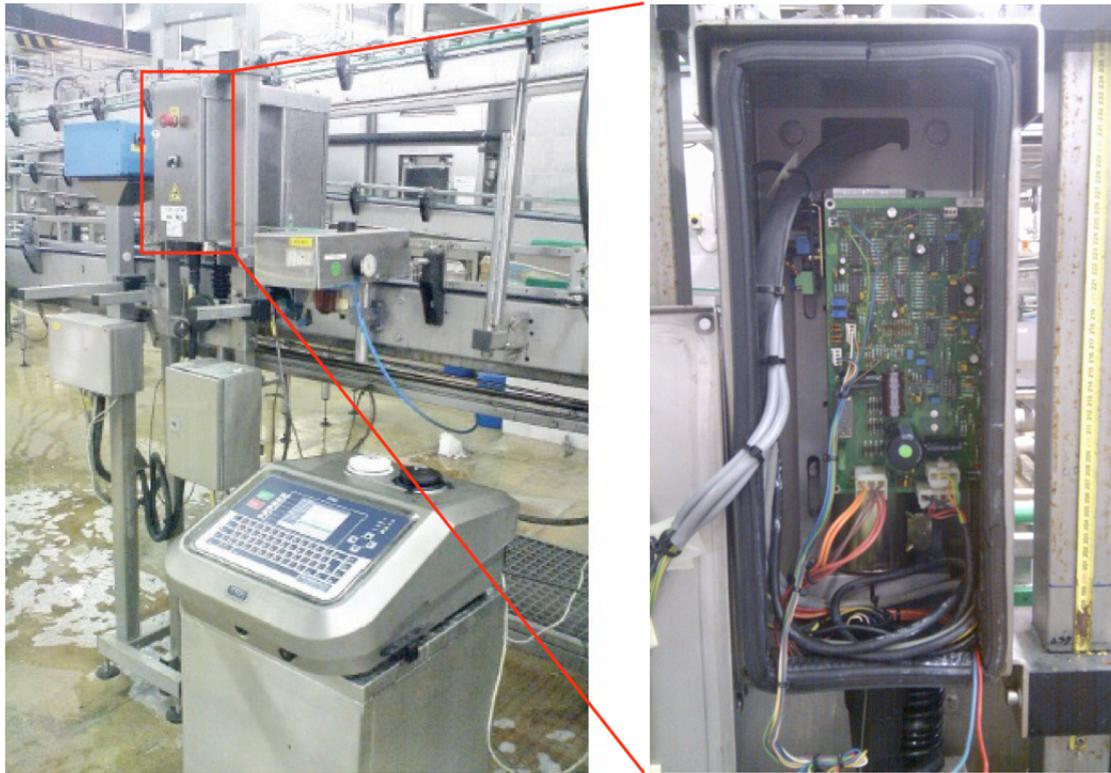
The original gauging system on the can filling line (left), and inside the gauge cabinet (right): the X-ray tube is mounted on the rear of the circuit board.
